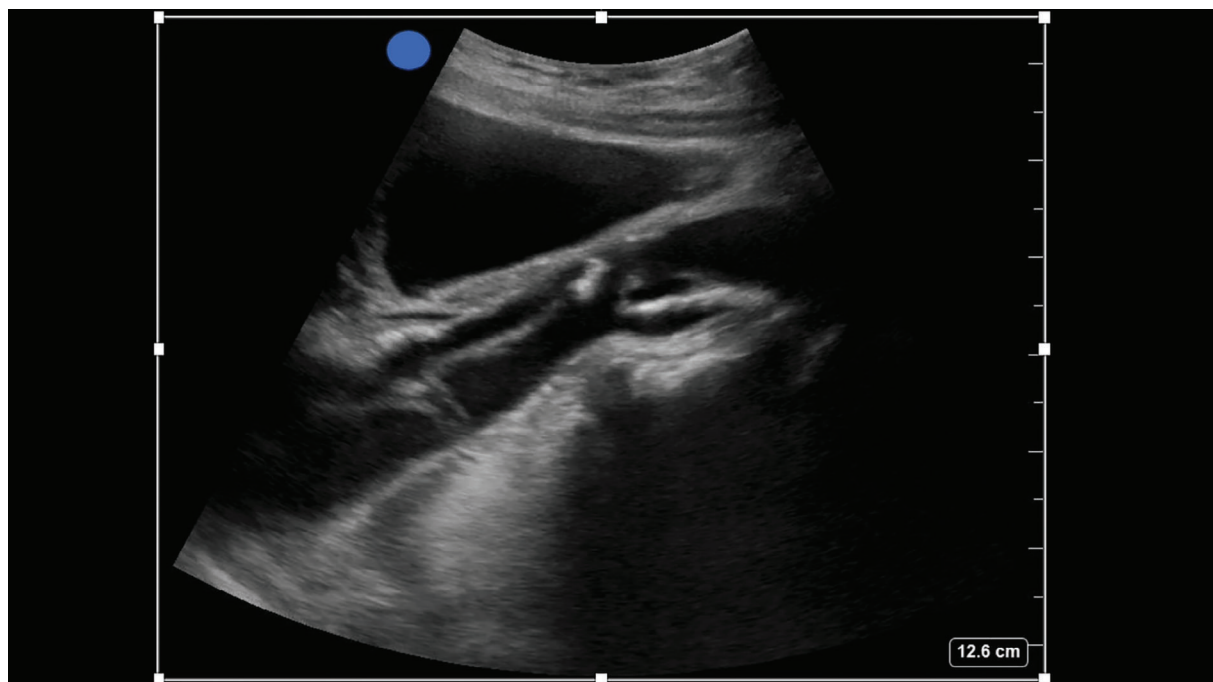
(A) Long axis abdominal ultrasound and (B) Computed tomography torso demonstrates contrast uptake (arrowheads) in the true/anterior lumen (asterisk). Pulse-wave Doppler flow over the anterior/true (C) true lumen exhibits spectral broadening depicting mild flow disturbance (bracket), whereas the posterior/false (D) lumen demonstrates greater reverse flow (arrow).
